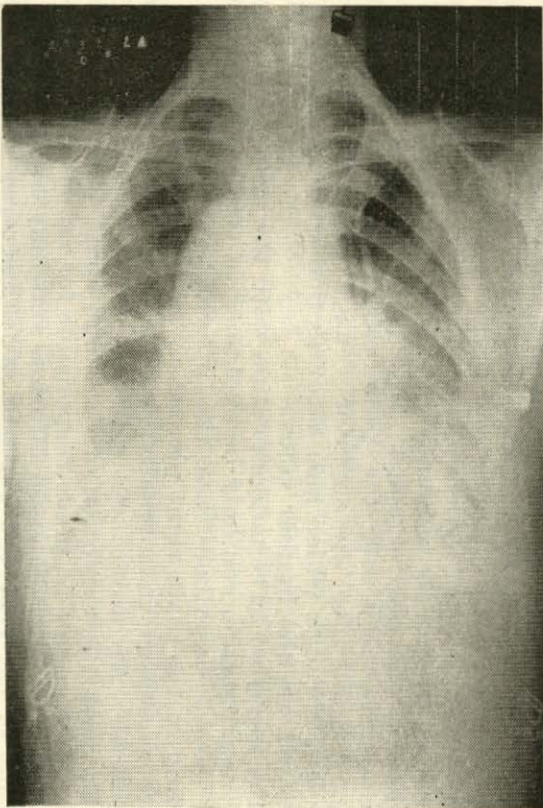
X-ray on 5-27-45, the interlobar effusion has disappeared but there is free fluid in both sides, the heart is more enlarged than previously.
